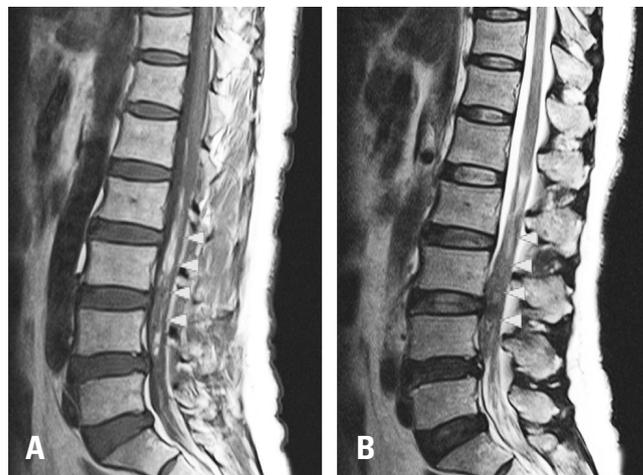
Spinal subarachnoid hematoma. Magnetic resonance imaging showed subarachnoid hematoma extending from L2 to L5. Cauda equina compression with subarachnoid hematoma was most severe at the L3-4 level. (A) Hyperintense in a T1-weighted image, (B) Hypointense in a T2-weighted image.
